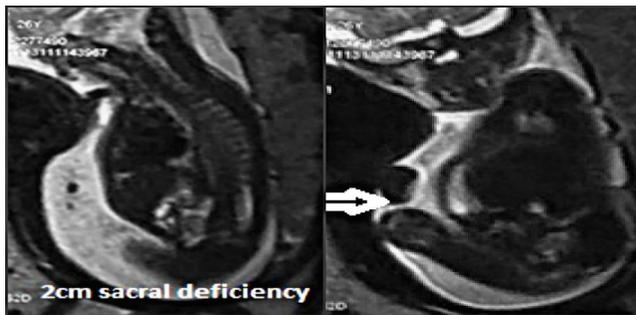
Fetal MRI showing sacrum deficiency, extrophy of bladder and herniation of bowel (white arrow).
